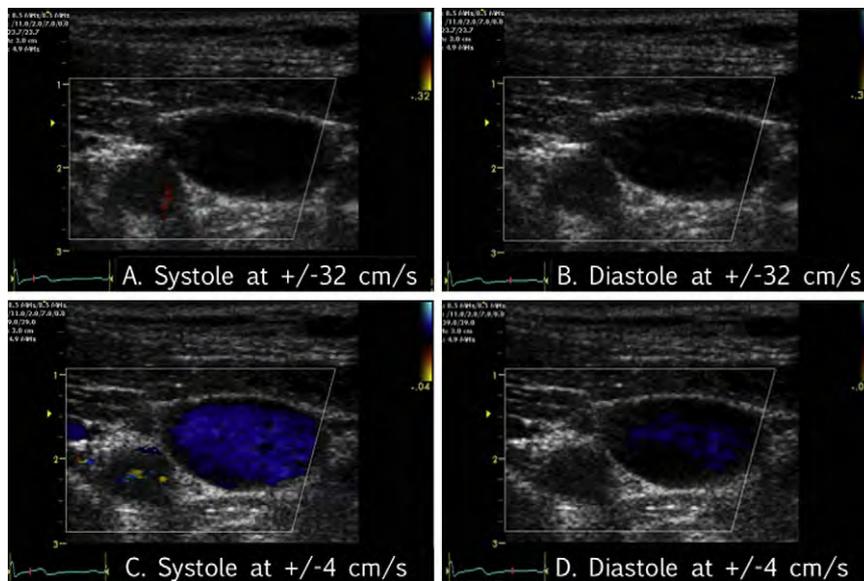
Vessel identification with color flow Doppler. Arterial flow is visible in systole only, irrespective of Nyquist limit. Venous flow is visible in systole and diastole, but only if the Nyquist limit is sufficiently decreased.
